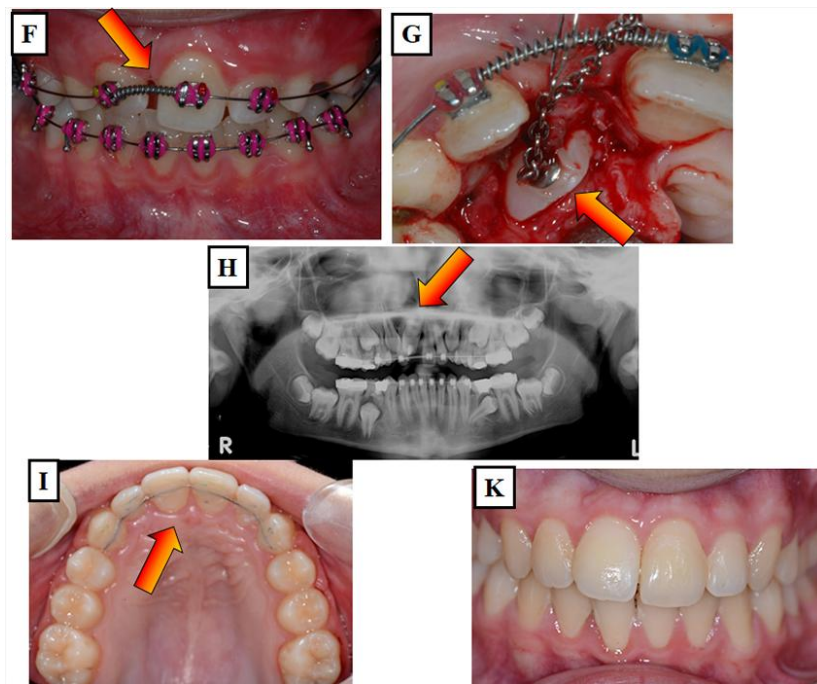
A-K: Clinical and radiographic presentation of an impacted, dilacerated maxillary central incisor.
